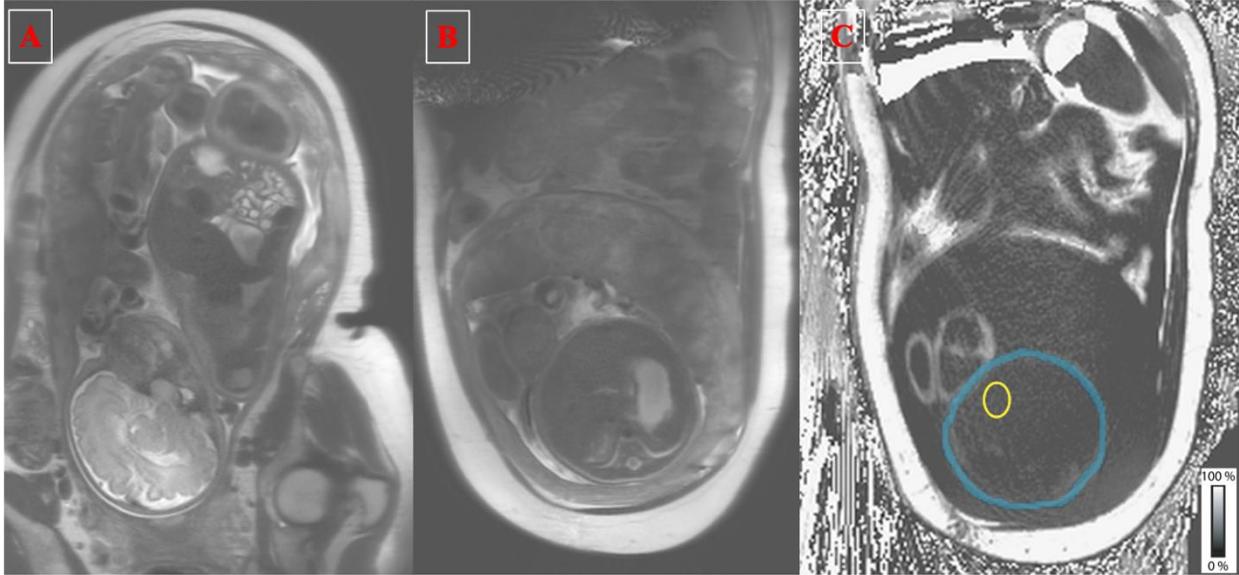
Fetal body composition measurements on MRI. This figure shows a fetus whose mother has gestational diabetes. A. Image from a sagittal T₂-weighted (T₂W) half-Fourier acquisition single-shot turbo spin-echo (HASTE) sequence. B. Image from an axial T₂W HASTE sequence. C. Proton-density fat fraction (PDFF) map from a free-breathing 3-D stack-of-radial gradient echo sequence. As shown by the grayscale bar for PDFF values (0-100%), white pixels have high fat content and dark pixels have low fat content. The images in B and C are matched at the level of the lower liver. The blue annotation represents fetal subcutaneous fat. The yellow oval is a 3-cm² region of interest used to measure fetal hepatic PDFF.
